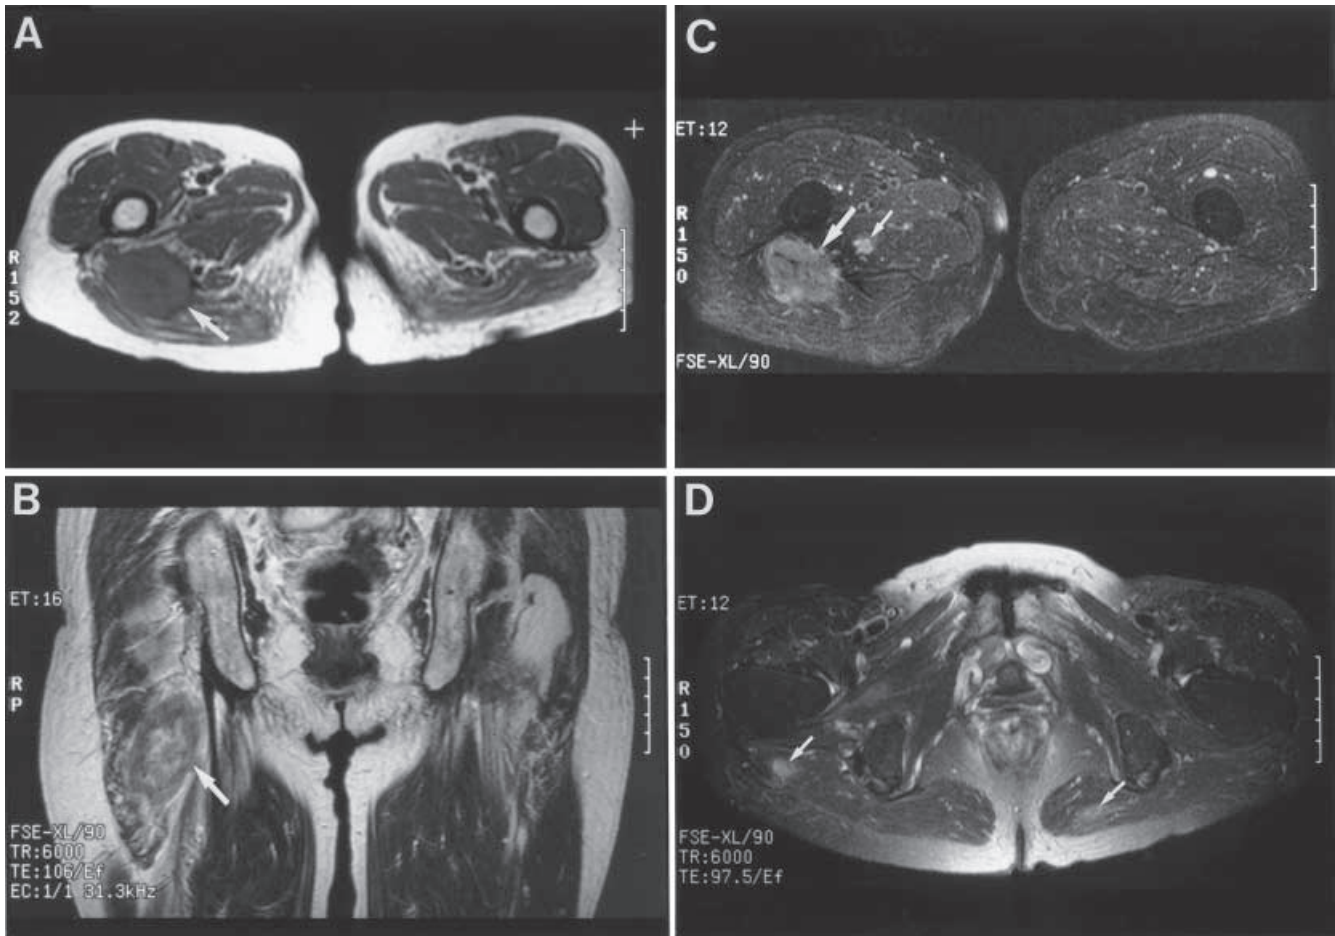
Magnetic resonance imaging (MRI), showing intramuscular metastasis in the gluteus maximus muscle. MRI revealed iso-signal intensity (*arrow*) on the T₁-weighted axial image A (repetition time [TR]/echo time [TE]: 600/14) and high signal intensity (*arrow*) on the T₂-weighted coronal image B (TR/TE: 6000/106) compared with surrounding muscles.
